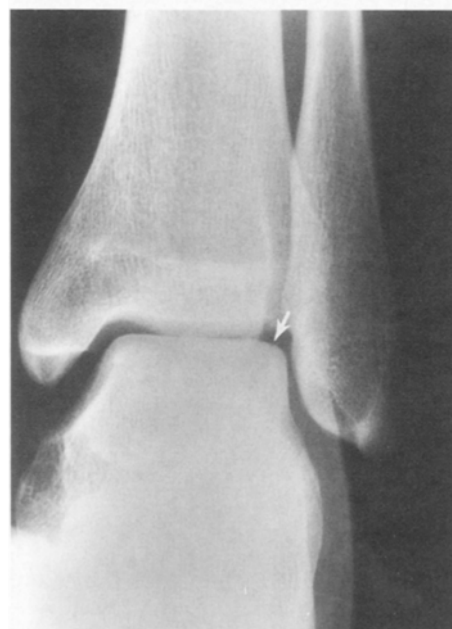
Osteochondral fracture of the talus. AP radiograph shows very subtle cortical stepoff (arrow), which was overlooked on initial review. Fracture was noted on follow-up radiograph.
